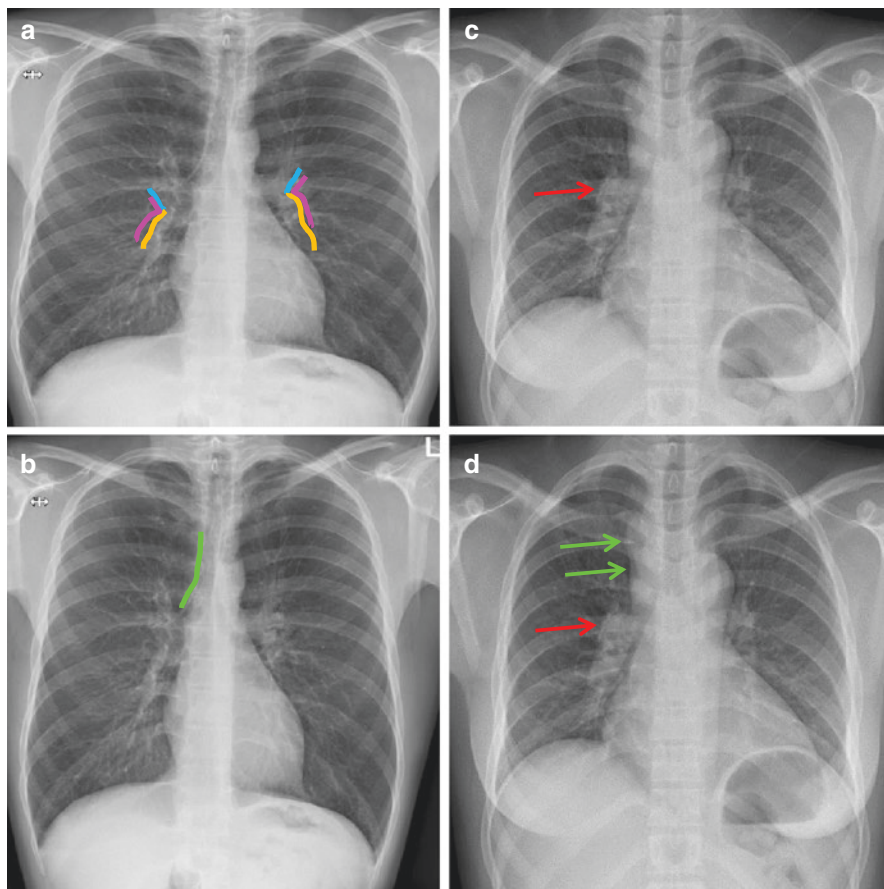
(a) A normal frontal chest radiograph. The pink lines delineate normal hilar points, made up of the intersection between the upper lobe pulmonary veins (lateral borders delineated by the blue lines) and the lower lobe pulmonary veins (denoted by the orange lines). The left hilar point should always be above the right hilar point on a normal chest radiograph. (b) Normal right paratracheal stripe constituted by the soft tissue density tracheal wall against a lung air interface. (c and d) Thickened right paratracheal stripe with a lobulated lateral contour (green arrows) with obscuration of right hilar point by enlargement of the right hilum (red arrows). CT subsequently confirmed typical caseous nodal disease in both locations
